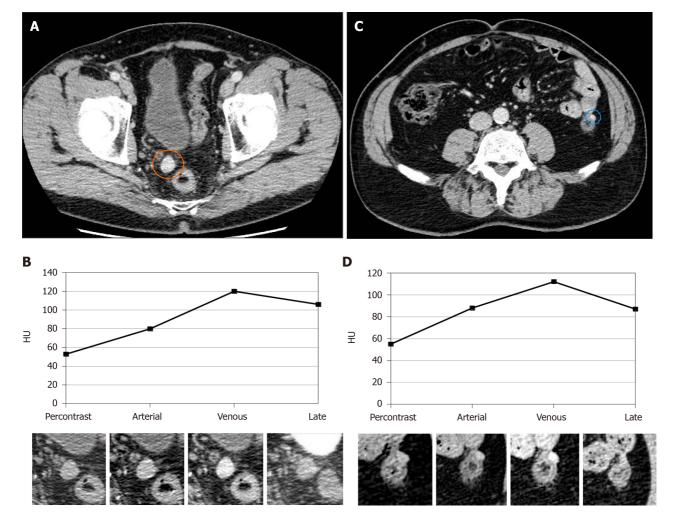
Computed tomography examination. A: Multiphase contrast-enhanced computed tomography (CT) examination shows a rounded, smooth marginated nodule in the right recto-vesical space; B: Spleen-like vascularization, characterized by progressive contrast uptake in the arterial and venous phases and partial washout in the late phase; C and D: A further, smaller nodule with similar CT features can be seen adjacent to the left colon. HU: Hounsfield units.
